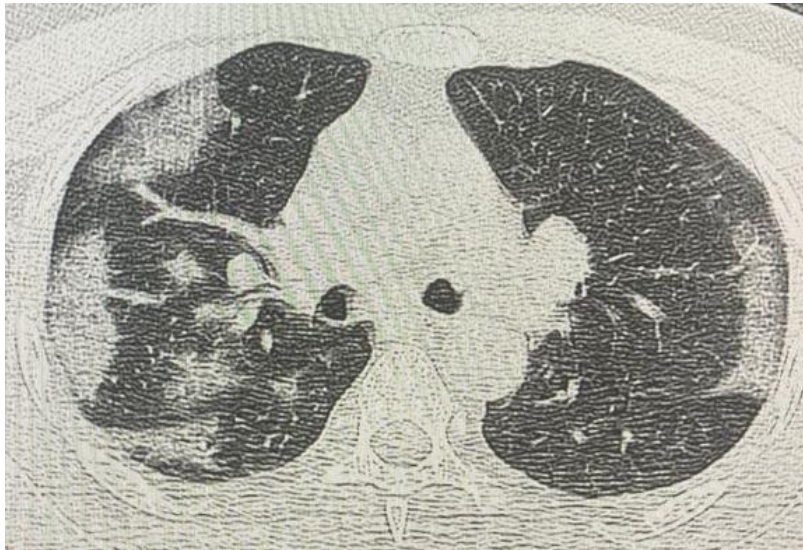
HRCT chest scan on Follow up showed persistence of opacities and interstitial septal thickening.
